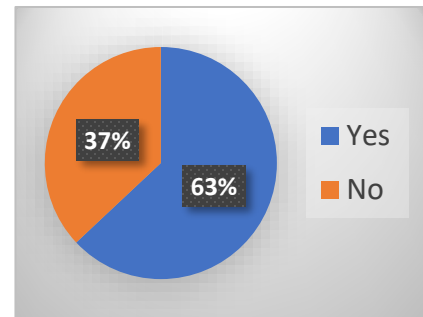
Does your office offer pre-trial services for DWI defendants?
